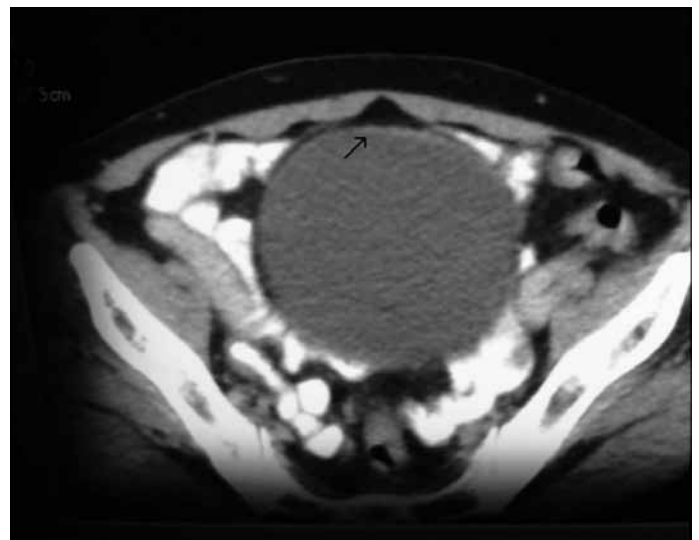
Computed tomography revealing a contrast-enhanced thickness of the of the bladder dome.
